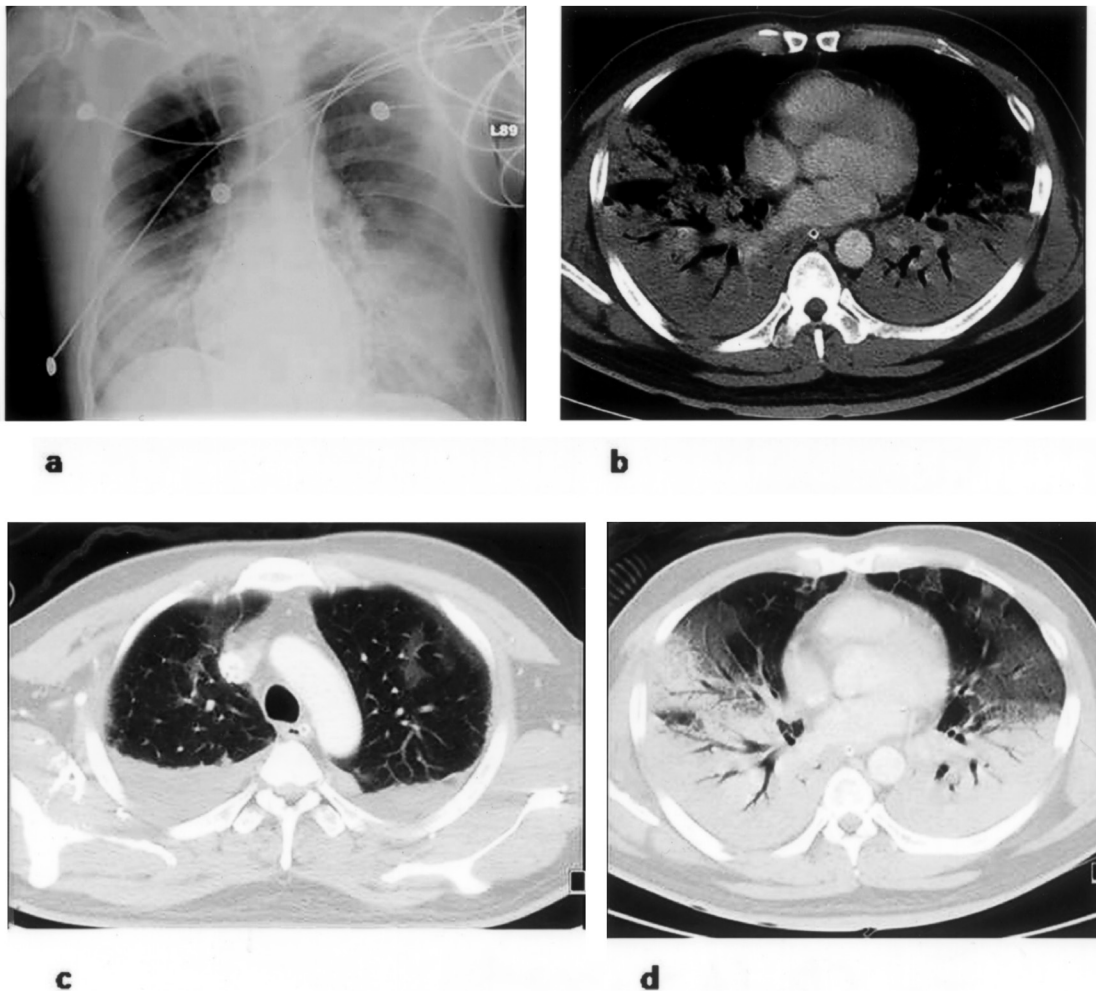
Chest radiograph (a) shows consolidations in bilateral lower lung fields. Thoracic HRCT scans (b,c,d) reveal consolidations in the dependent lungs, particularly in the lower lung fields, and multiple ground-glass opacities.
